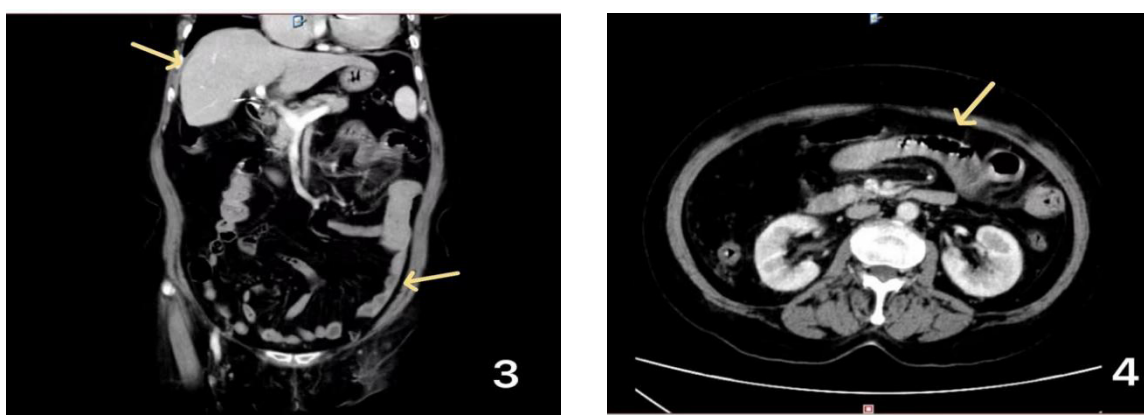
CT imaging revealed that the obstruction disappeared and the effusion decreased.
